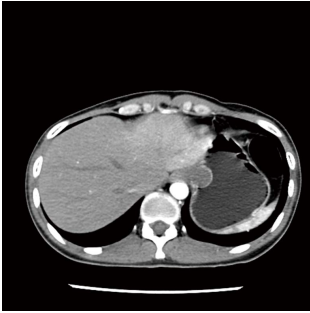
Computed tomography revealed a tumor located in the gastric fundus adjacent to gastric cardiac region.
